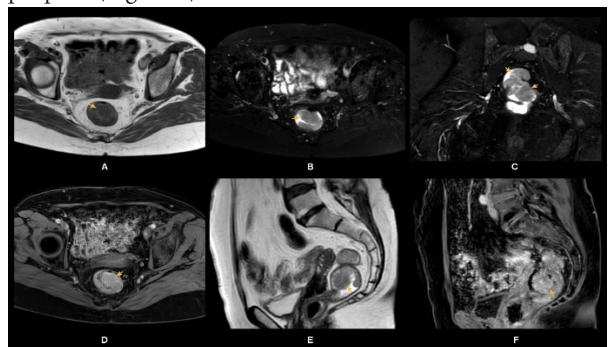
Pelvic magnetic resonance imaging shows a polypoid mass lesion (arrows) that is hypointense on T1 weighted images (WI) (A), isohypointense on axial (B) and coronal (C) T2 fat-saturated images, isohypointense on T2-WI (E), and minimal heterogeneous enhancement on post-contrast series (D, F). The lesion originates from the posterior wall of the rectum, extends from the proximal anal canal to the rectal lumen, and causes the intraluminal filling defect.
